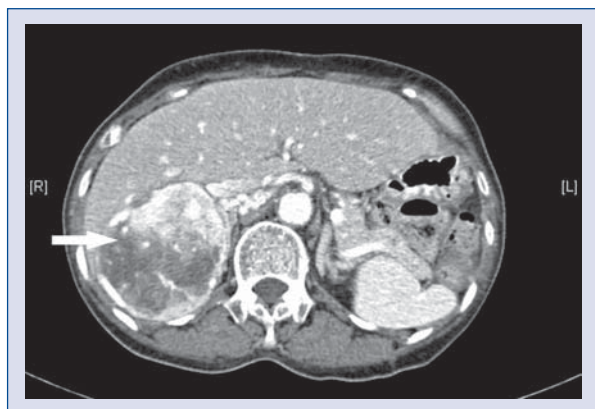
Computed tomographic scan of the abdomen showing a large right adrenal mass (indicated by arrow).
